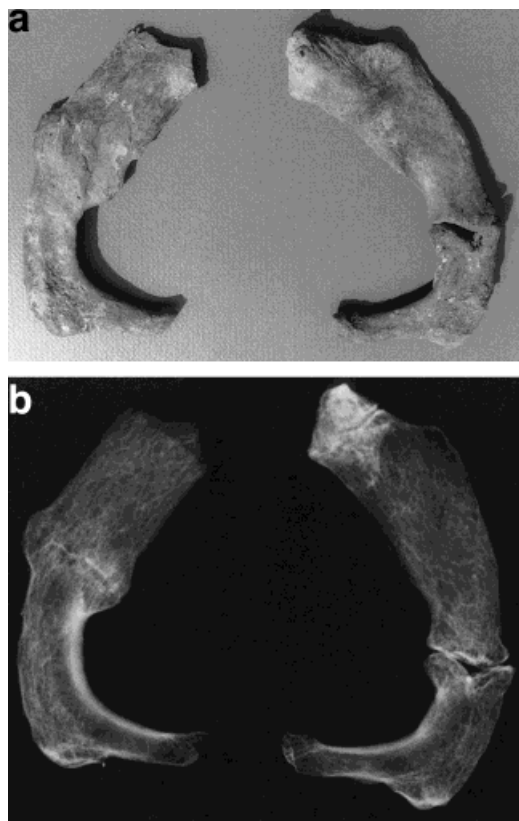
a: Bilateral fractures of the first ribs. The left was healed and the right has a nonunion fracture (case Acha 3C1, adult male). b: Radiograph of same case.
